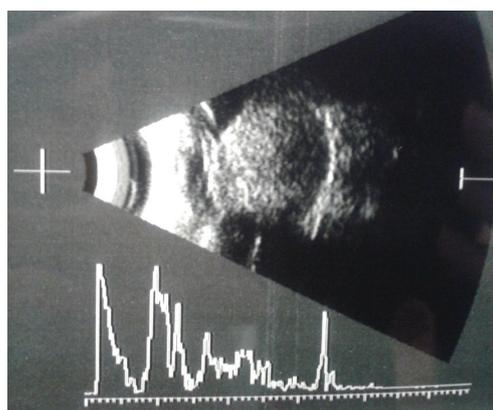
Ophthalmic B mode ultrasound showed a large homogenous mass in the vitreous cavity.
